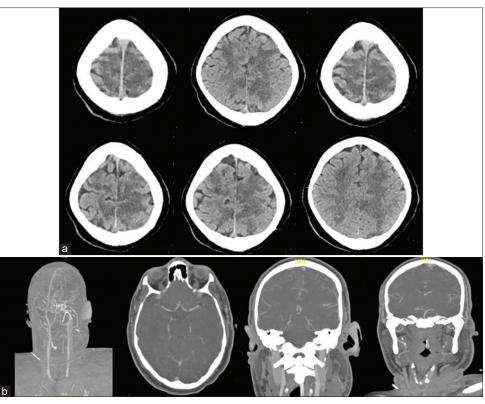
(a) Axial computed tomography head without contrast shows multiple cortical and subcortical hypodensities, edema, and loss of gray-white matter differentiation involving bilateral frontal lobes, bilateral superior parietal lobes, and bilateral occipitoparietal regions. (b) Computed tomography angiogram with contrast shows patent cerebral vessels
